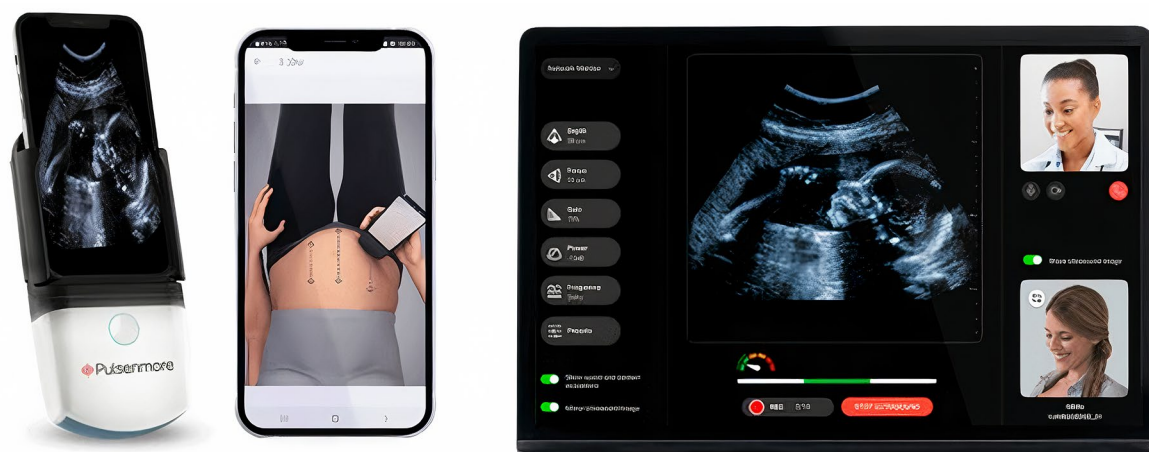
The Pulsenmore ES system, with a handheld ultrasound transducer smartphone cradle, a user application and clinician's dashboard for either. app-guided or clinician-guided mode
